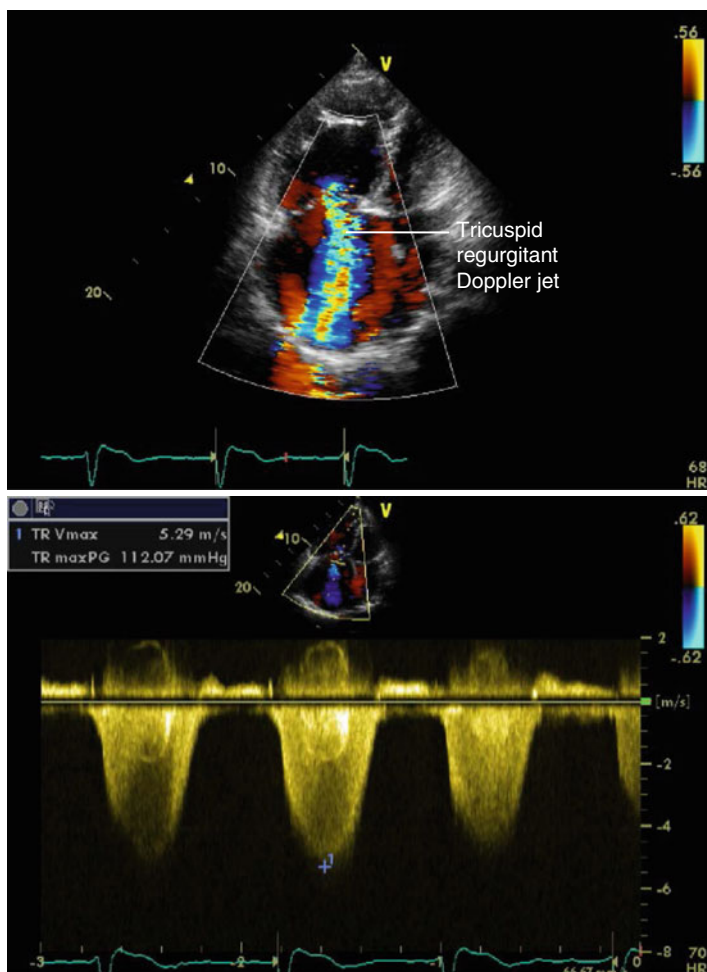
Pulmonary artery systolic pressure estimation by the continuous wave Doppler tracing of the tricuspid regurgitant jet velocity in a patient with pulmonary hypertension. From a tricuspid regurgitant velocity of 5.29 m/s the right ventricular systolic pressure can be calculated to 135–140 mmHg, equivalent to pulmonary artery systolic pressure in the absence of right ventricular outflow obstruction
